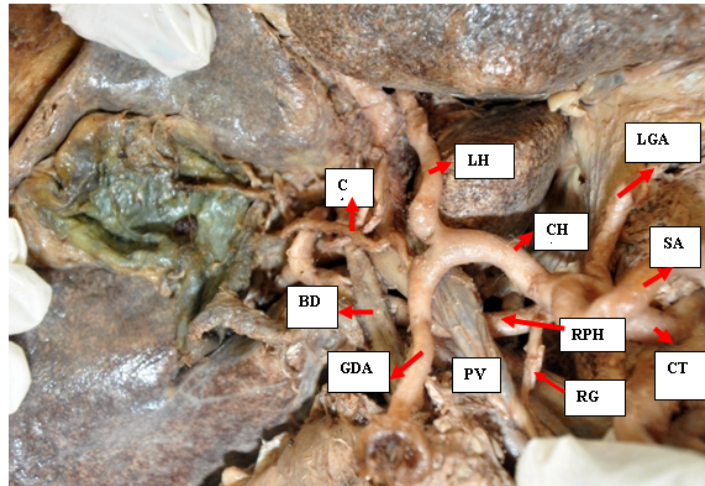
Quadrifurcation of CT; CT=Coeliac Trunk, RPHA=Right Proper Hepatic Artery, CHA=Common Hepatic Artery, LGA=Left Gastric Artery, SA=Splenic Artery, RGA=Right Gastric Artery, LHA=Left Hepatic Artery, GDA=Gastroduodenal Artery, CA=Cystic Artery, BD=Bile Duct, PV=Portal Vein
